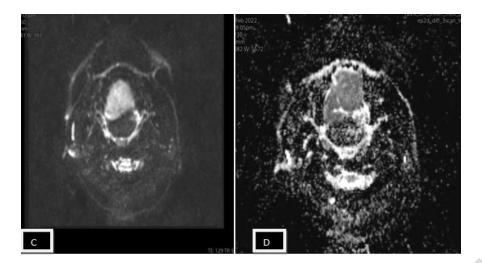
The image depicting the presence of diffusion restriction in the lesion noted on DWI and ADC images.
